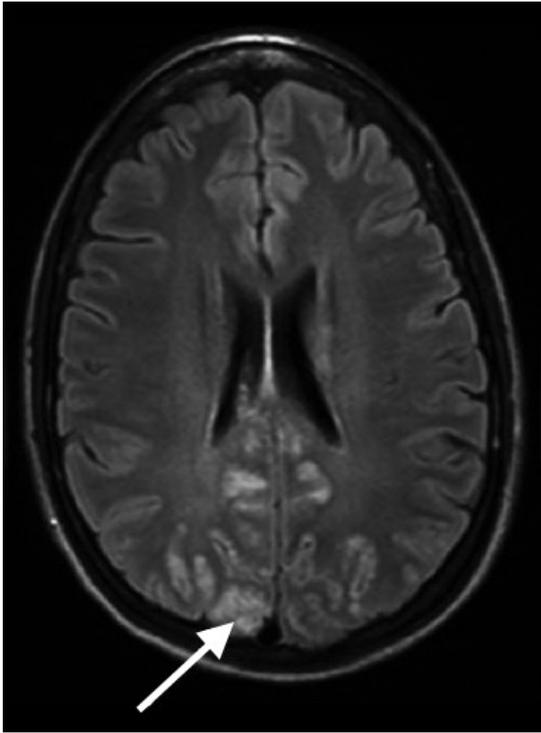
Magnetic resonance image showing small foci of FLAIR increased intensity, involving bilateral parieto-occipital parenchyma and left cerebellum
